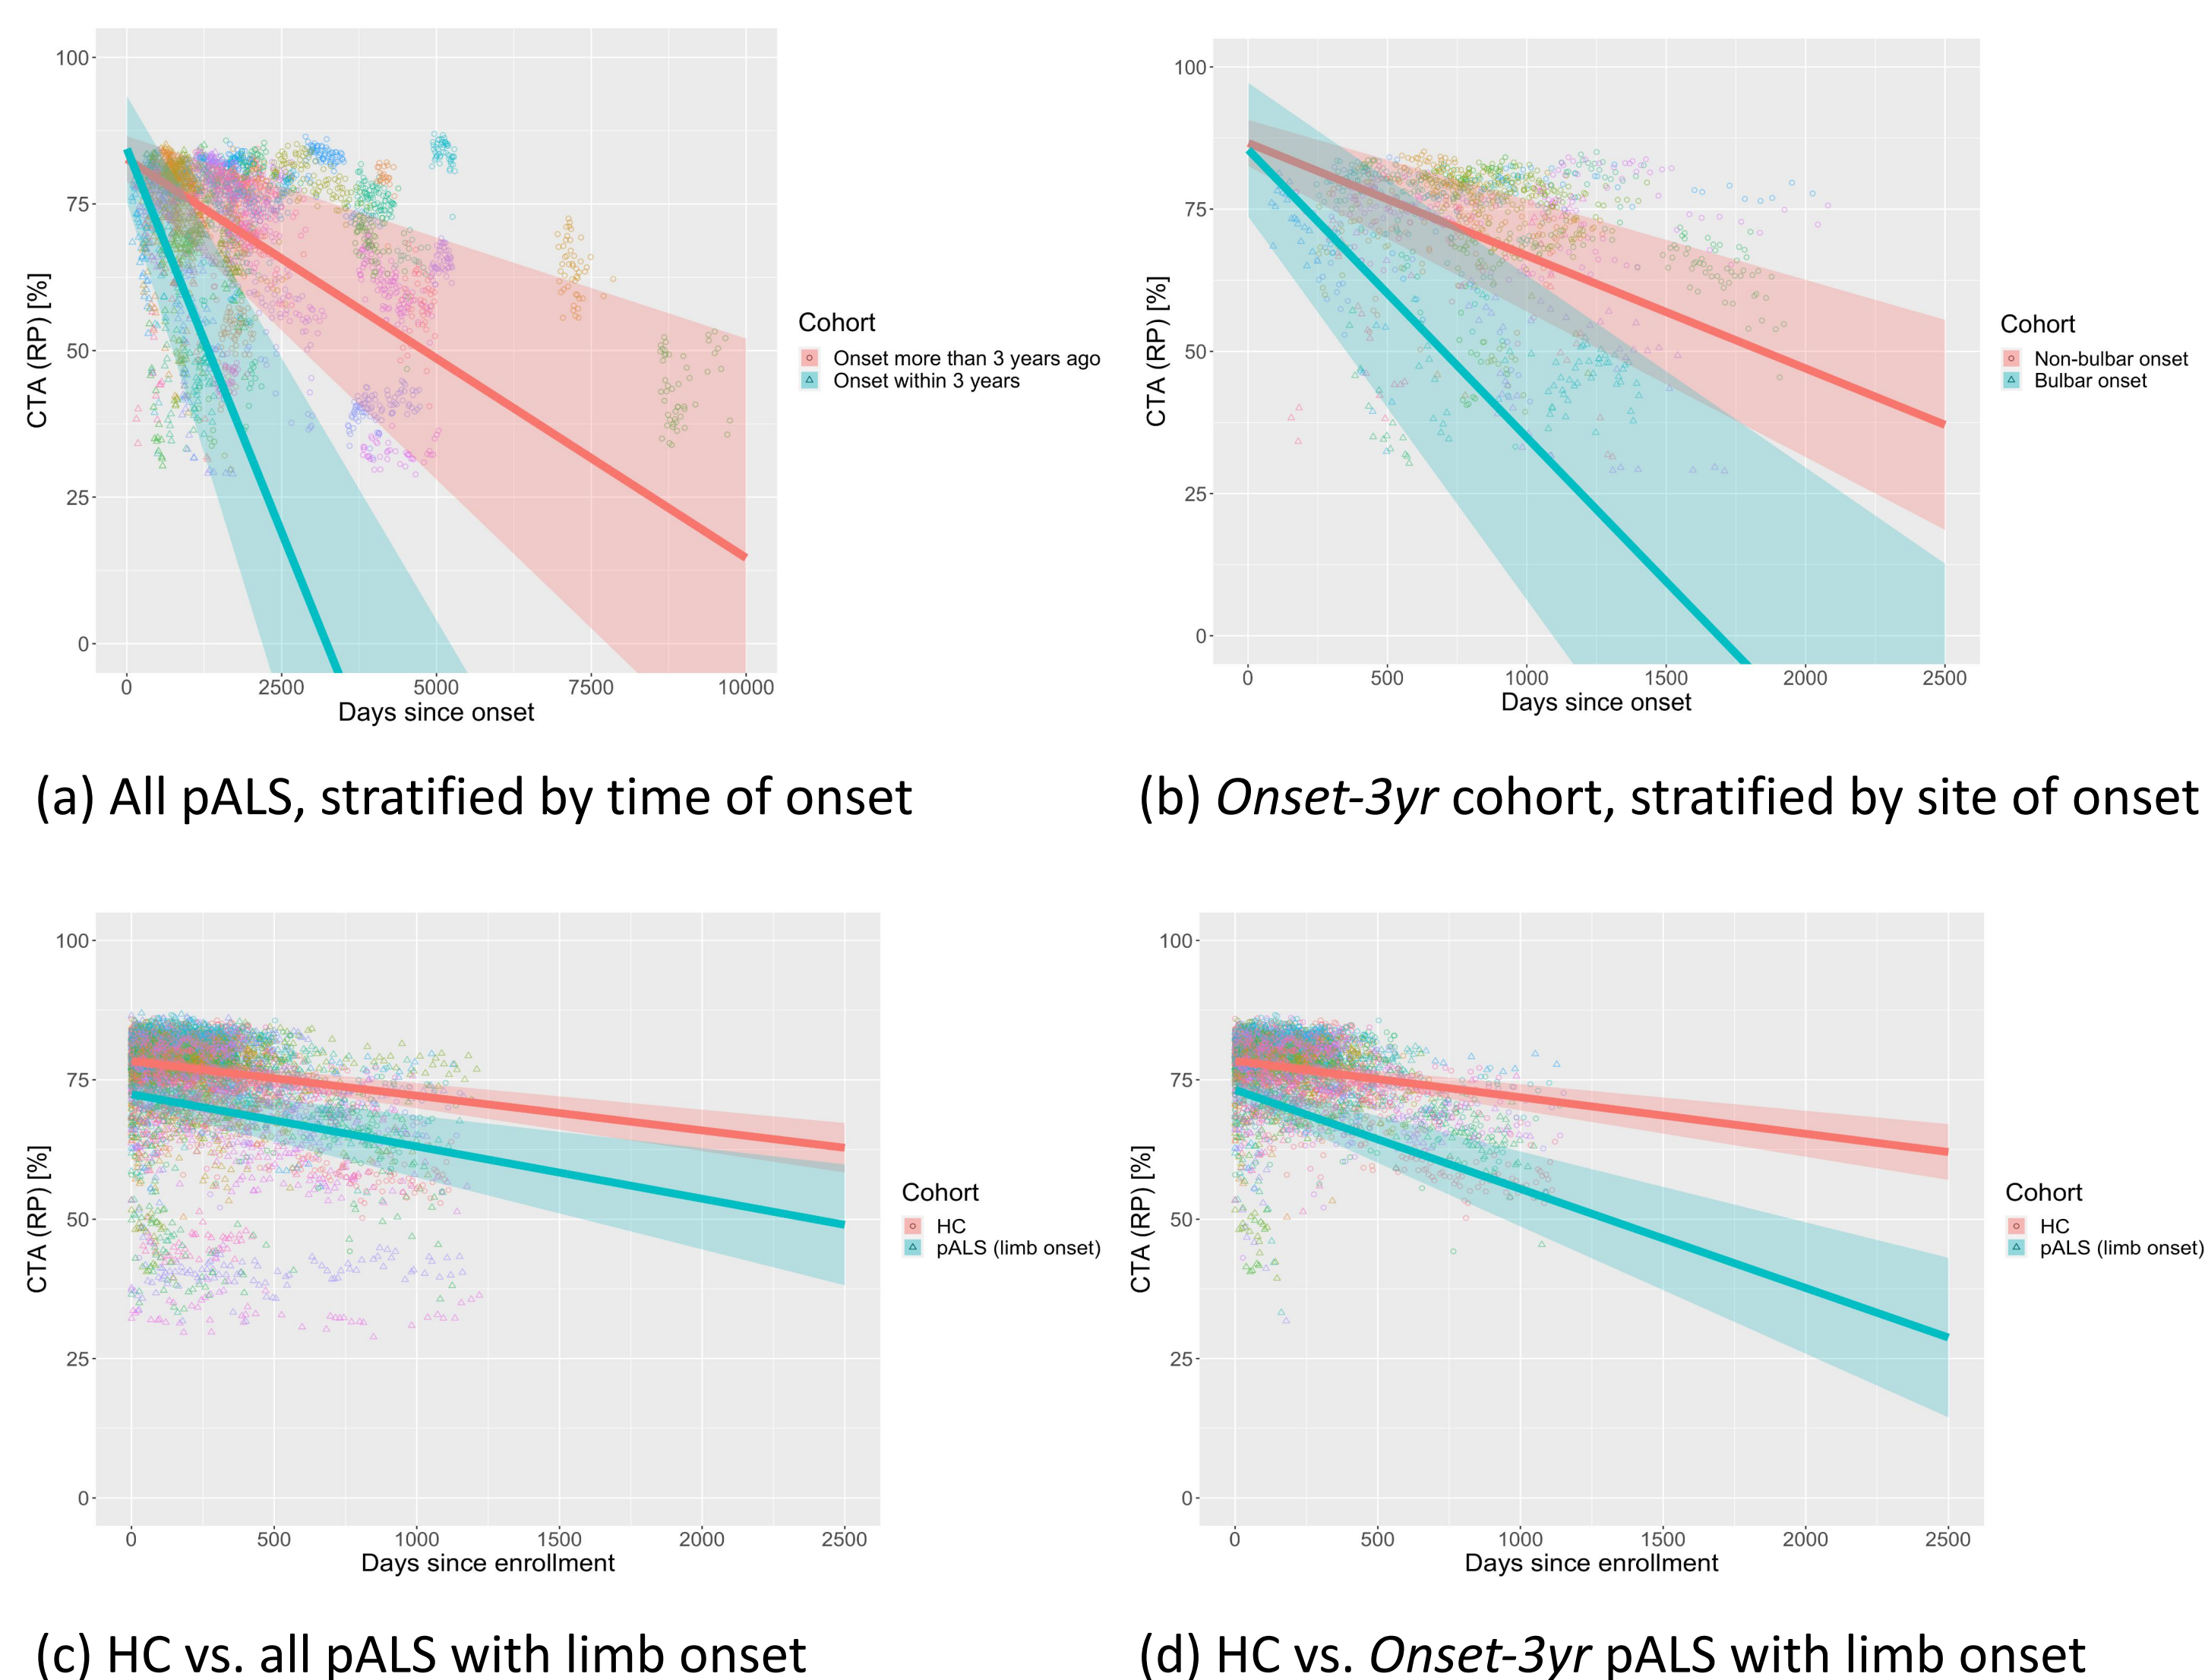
Longitudinal trajectory of CTA measures in different cohorts based on growth curve models.
